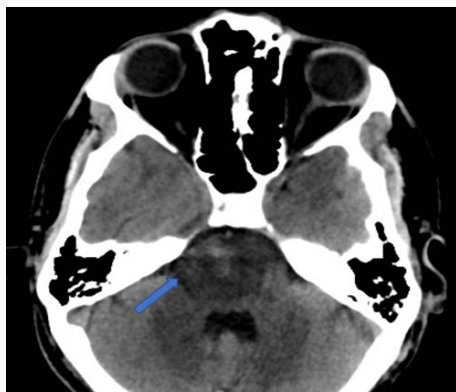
Pontine hemorrhagic transformation was demonstrated on CT.
